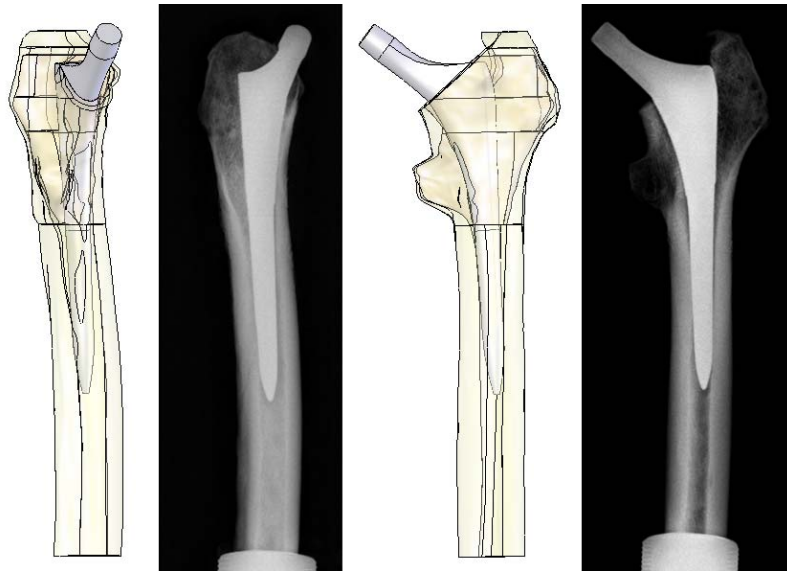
The positioning of the stem in femur 13L as used in the FE model compared with the post-operative radiographic images.¹
